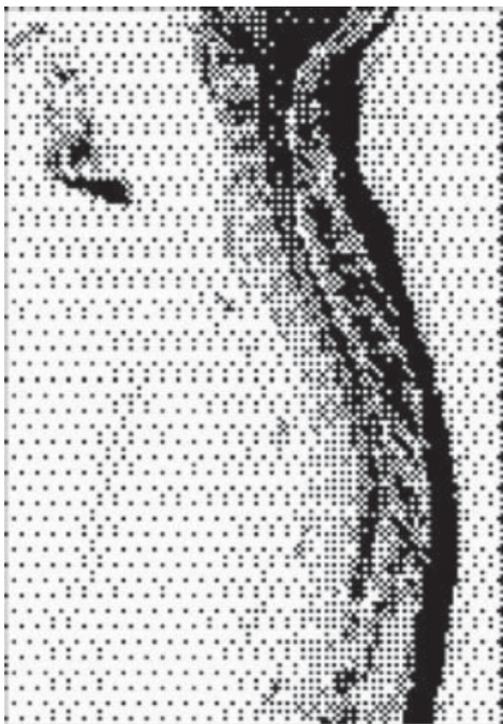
MRI of cervical and sacral cord in a young patient presenting with urinary retention. The patient had undiagnosed multiple sclerosis. Signal changes are seen in the cervical, thoracic, and lumbosacral cord.
